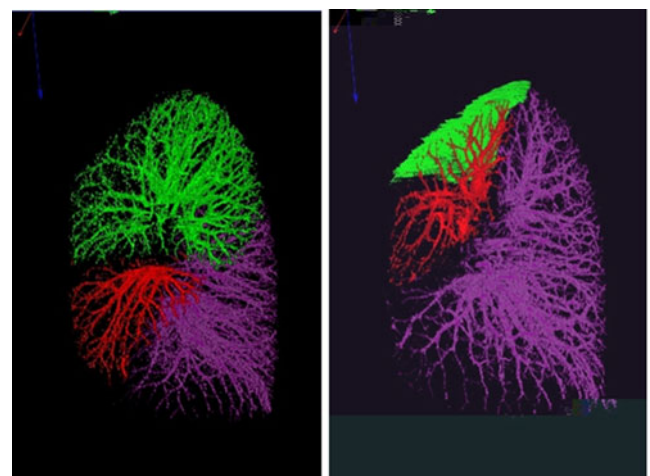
Segmented lobes of the right lung from a thin-section CT examination acquired at total lung capacity: a pre-treatment imaging; b following right upper lobe volume reduction
